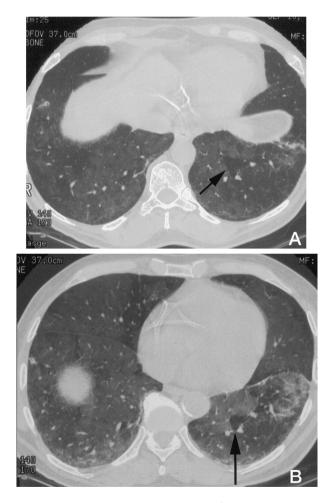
Top*, A: Inspiratory HRCT reveals mosaic attenuation at the lung bases. A lobular area of decreased attenuation in the left lower lobe is demarcated (black arrow). *Bottom*, B: Expiratory HRCT performed at approximately the same level as the above image. The lobular area of decreased attenuation in the left lower lobe remains lucent on expiration (black arrow). This confirms air trapping. Multiple other areas of air trapping are also present.
